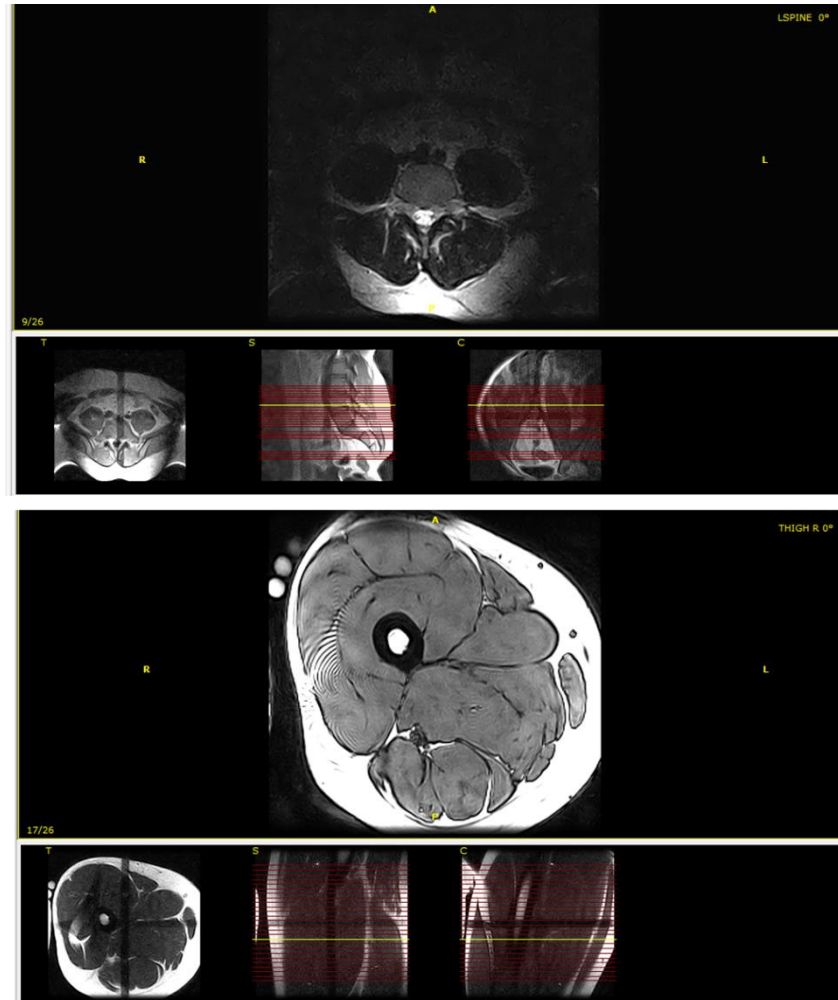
an example of lower back muscles (upper figure) and thigh muscles (lower figure) as scanned in MRI in one participant before the pandemic.
